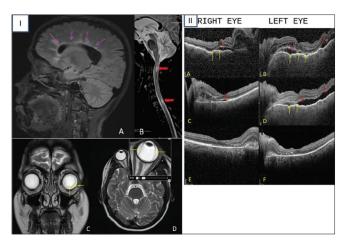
(I) A. Sagittal FLAIR image showing hyperintensities oriented perpendicular to periventricular margins (purple arrow) and calloso-septal interface suggestive of demyelinating lesions; B. Sagittal T2 image showing cervical and thoracic cord, short segment hyperintensities suggestive of demyelination (red arrow); C. Coronal T2 section showing choroidal detachment in the left eye (yellow arrow); D. Axial T2 section of the brain with inset image zoomed to show choroidal detachment (yellow arrow) suggestive of uveitis. (II) (A and B) OCT image at presentation shows multiple areas of neurosensory detachment (red arrow), increased undulation of retinal pigment epithelium (yellow arrow), intra-retinal fluid and hyperreflective dots and vitreous cells with disc oedema; (C and D) After three doses of IV methylprednisolone - reduction in neurosensory detachment and decrease in the retinal pigment epithelium's undulations (E and F). At 1-month follow-up on oral steroids and azathioprine - OCT shows complete resolution of sub-retinal fluid and retinal oedema
